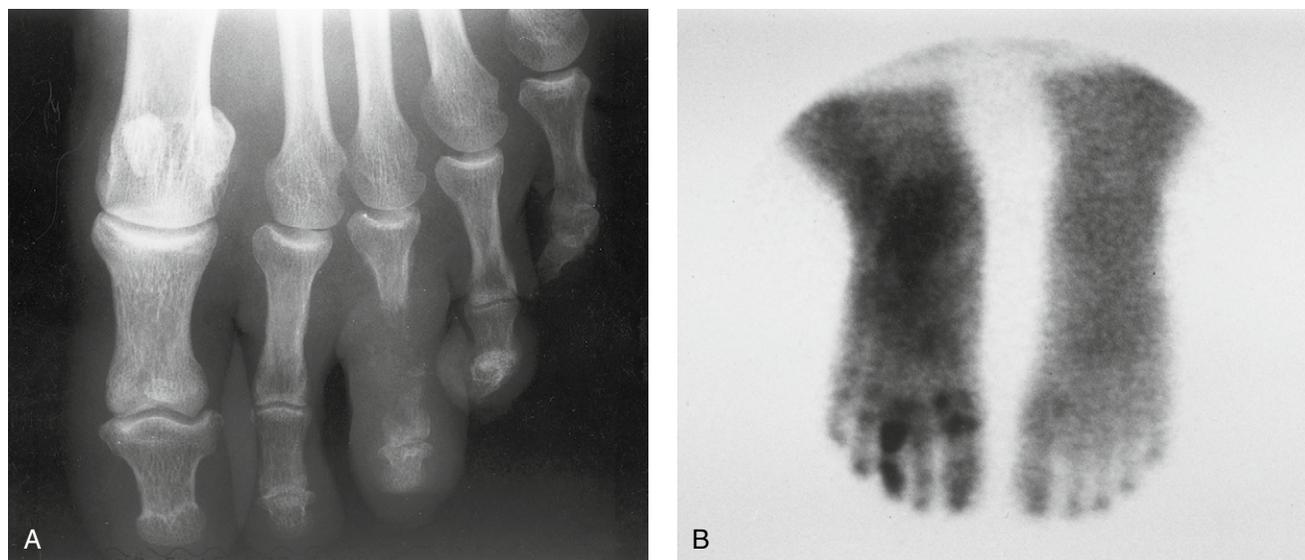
Roentgenograms (A) and technetium pyrophosphate nucleotide scan (B) in a diabetic patient with osteomyelitis and tenosynovitis due to *Candida albicans*. The patient presented with a diabetic foot ulcer of the third toe, which failed to heal despite prolonged antibiotic therapy. Plain films showed destruction of the proximal and middle phalanges (A). The bone scan showed corresponding activity, with diffuse labeling over the tarsal bone most consistent with increased perfusion (B). On resection, the bone was grossly involved, as was the extensor hallucis longus tendon and tendon sheath (Reproduced with permission from Kemper CA, Deresinski SC. Fungal disease of bone and joint. In: MacKenzie DWR, Odds FC, Kibbler CC (eds) Principles and Practice of Clinical Mycology. John Wiley, Chichester, Sussex, 1996).
